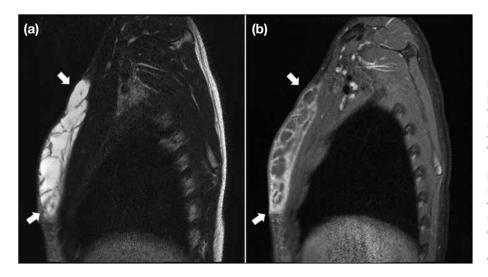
A 14-year-old boy presented with right breast swelling for 6 months. (a) T2-weighted magnetic resonance imaging (MRI) with fat saturation. (b) Post-contrast T1-weighted MRI with fat saturation. MRI shows a multiloculated T2hyperintense mass with thin internal enhancing septations in the subcutaneous layer of the right upper anterior chest wall (arrows). No enhancing solid component was seen. Fine needle aspiration confirmed the diagnosis of lymphangioma.
